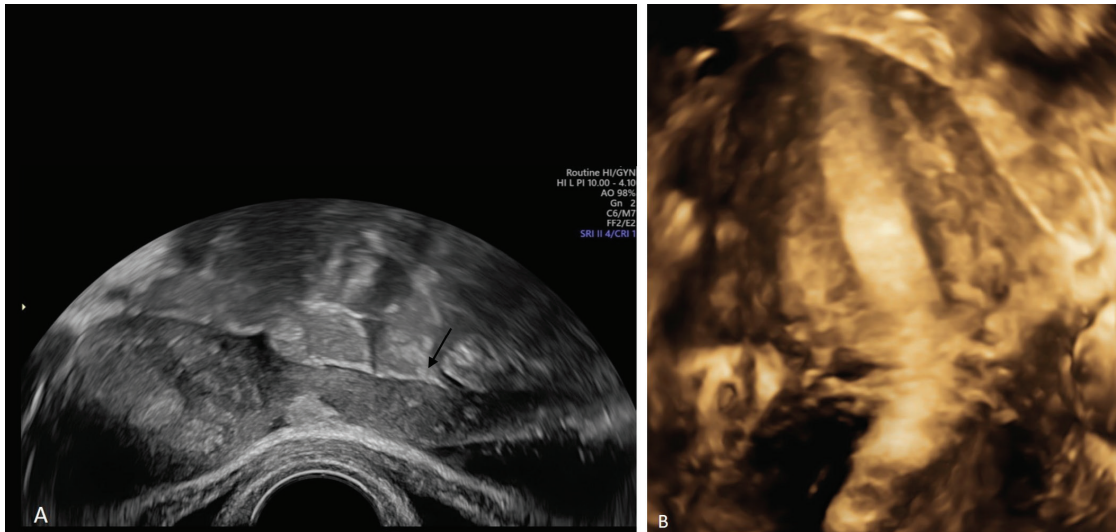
(A) Preoperative two-dimensional transvaginal ultrasound. The cross-section reveals a uterus deviated markedly to the left and a rudimentary horn with a small hyperechoic island of endometrial tissue. (B) Preoperative three-dimensional transvaginal ultrasound. The coronal plane reveals a markedly left-sided uterus and only one ostium of the fallopian tube and a narrow, elongated uterine cavity. The finding was confirmed on hysteroscopy. This patient has a non-communicating rudimentary horn
